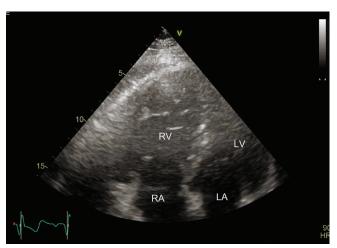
Transthoracic echocardiography shows the right ventricular dilation and dysfunction. RV = Right ventricle, LV = Left ventricle, RA = Right atrium, LA = Left atrium
